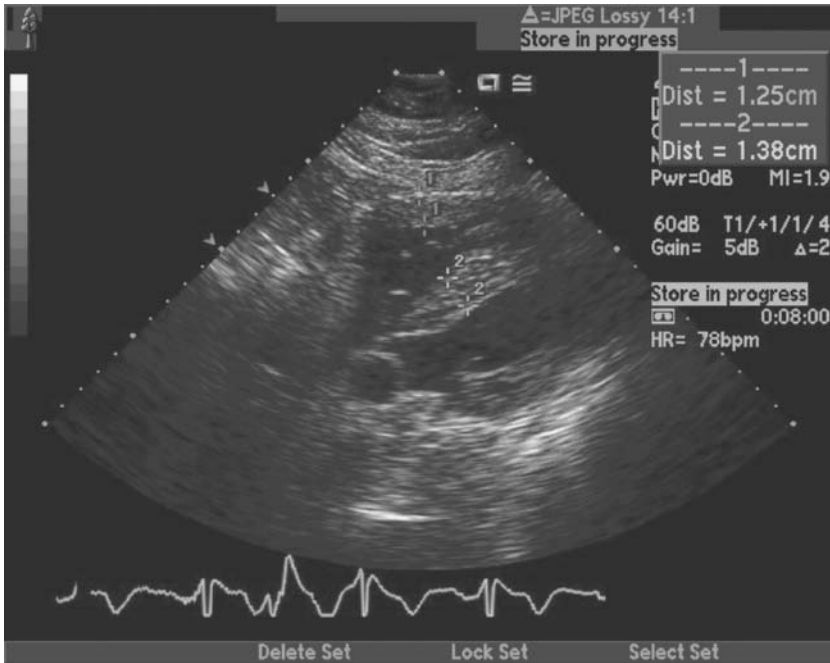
Echocardiography reveals significant right ventricular hypertrophy in the subcostal view. (Courtesy of Dr. George Cohen.)
